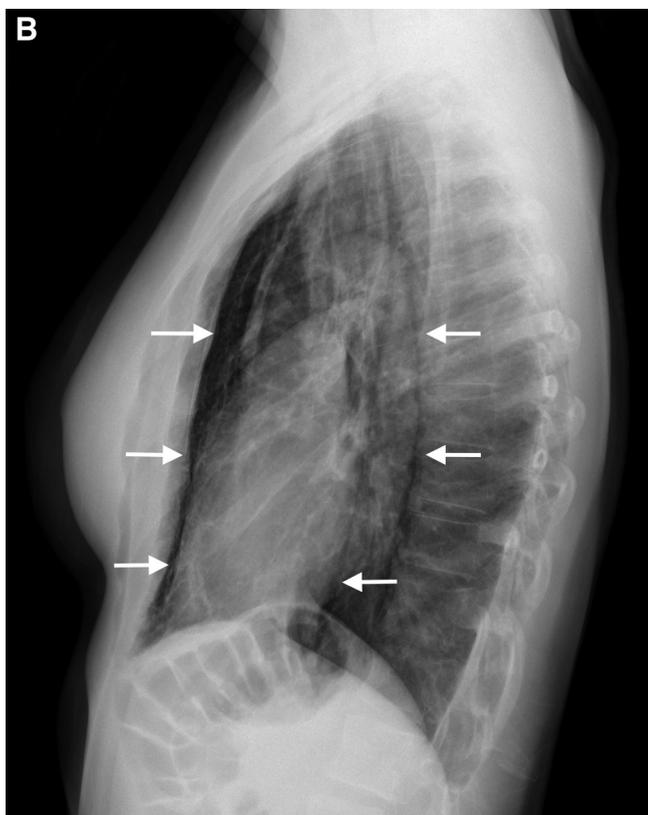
Chest radiograph lateral view showing small pneumomediastinum (white arrows).
